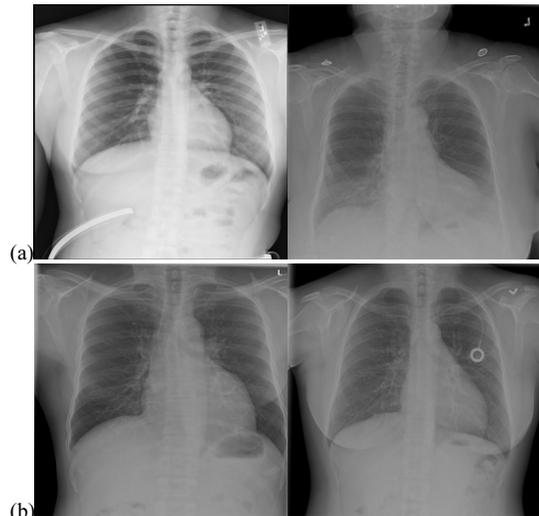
(a) X-ray Images for Patients without Cardiomegaly.
